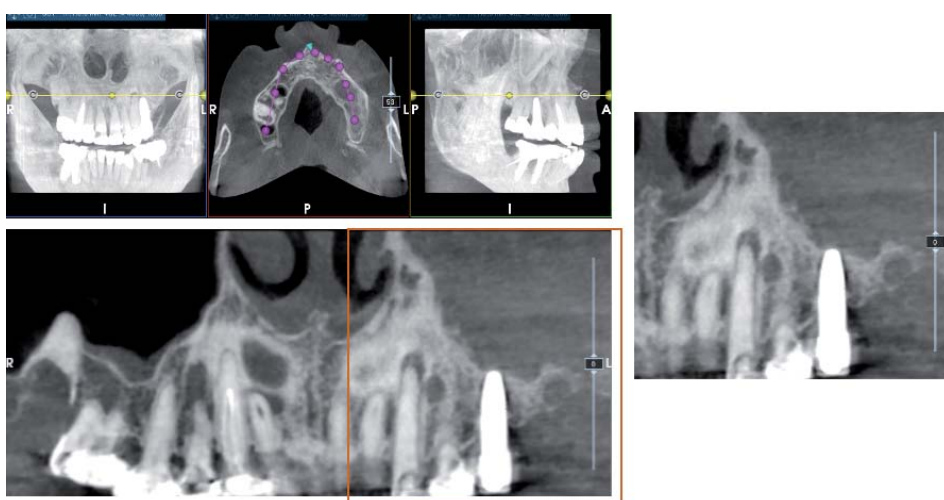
IIB CLASS: Mucosal thickening >5 mm CBCT of a patient. The arrow indicates the maximum mucosal thickness. Dental root protrudes inside the maxillary sinus floor. There is a need for dental treatment.
